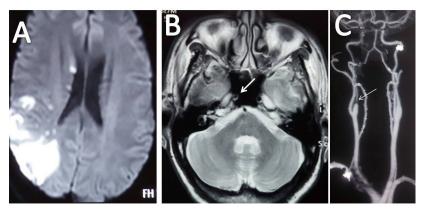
Partial flow void. Diffusion weighted-MRI (A) shows acute infarct in right middle cerebral artery territory; T2 Weighted-MRI (B) shows partial flow void signal in right ICA (arrow) and CT Angiography of neck vessels shows severe stenosis of the cervical portion of right ICA (arrow).
